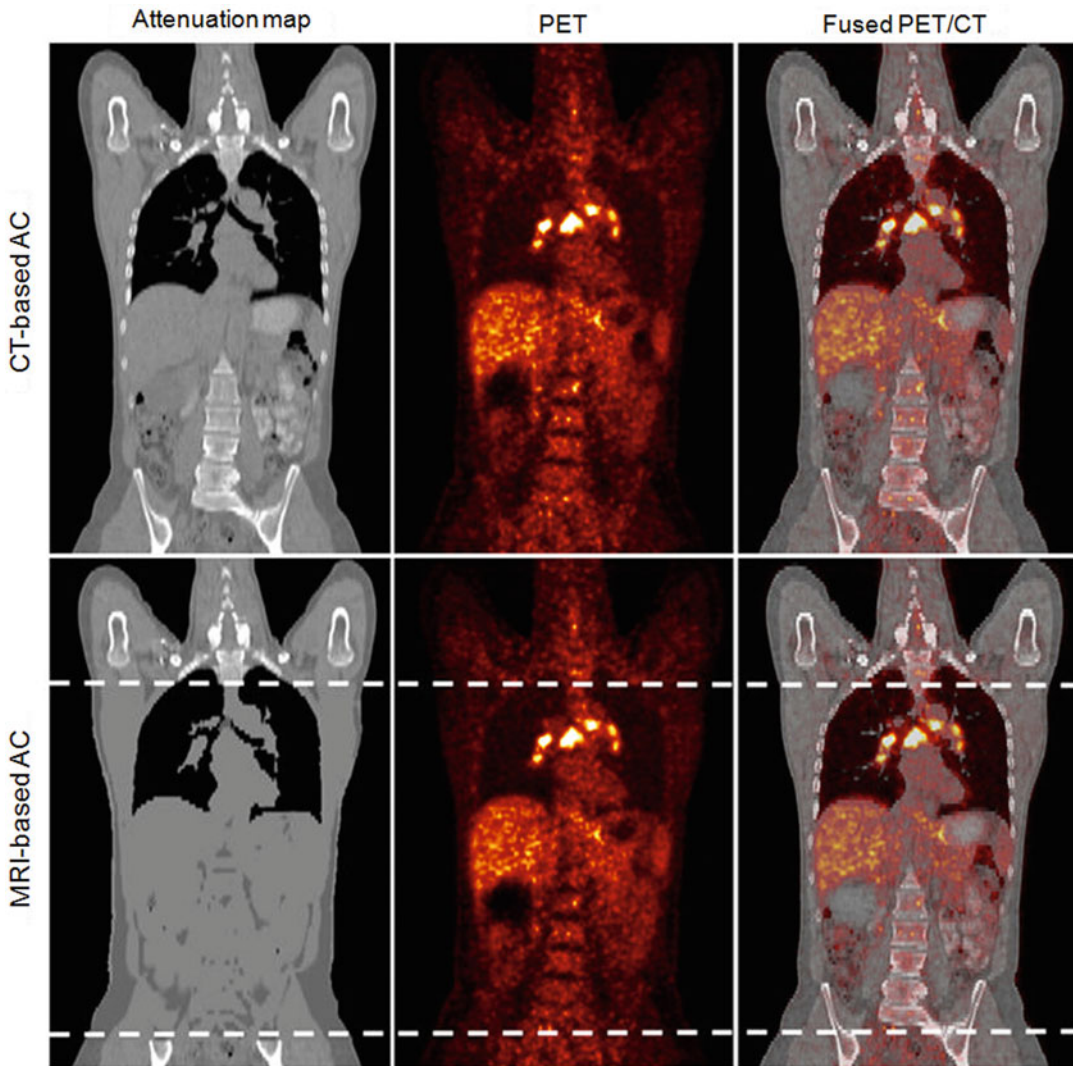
Attenuation correction (AC) of whole-body PET images using MRI segmentation based on two-point Dixon sequence (Reprinted from [20] with permission)
